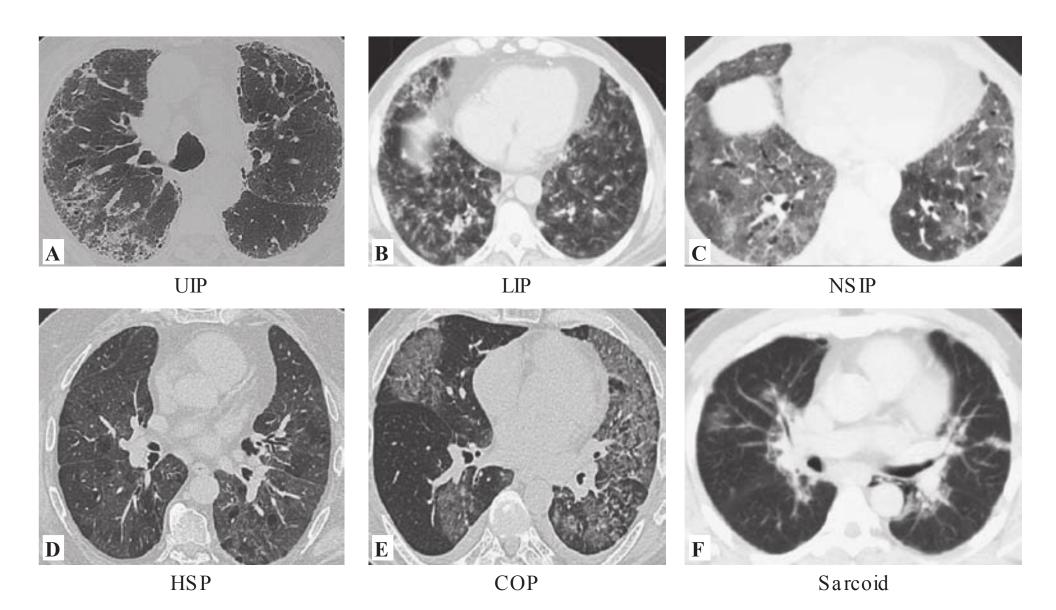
Representative computed tomography (CT) patterns that can be seen in patients with interstitial lung disease (ILD). ILD can be characterized by many different radiographic patterns. With the exception of usual interstitial pneumonia (UIP), there is substantial overlap among different forms of ILD. Anumber of the patterns are shown with the associated pathology noted. (A) Usual interstitial pneumonia (UIP) is characterized honeycombing, traction bronchiectasis and increased reticular markings. (B) Lymphocytic interstitial pneumonia (LIP) may demonstrate a micronodular pattern. (C) Nonspecific interstitial pneumonia (NSIP) often appears as a diffuse GGO. (D) Hypersensitivity pneumonitis (HSP) appears as a nearly homogeneous pattern of GGO. (E) Cryptogenic organizing pneumonia (COP) appears as a patchy infiltrate which may be GGO or dense. (F) Sarcoid can present with bronchovascular infiltrates and hilar adenopathy.
